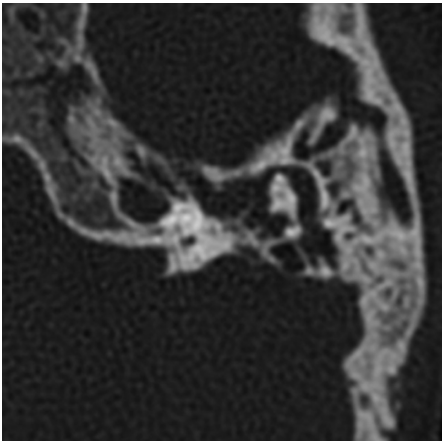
HRCT temporal bone, axial sections, bone window shows CLA with aplastic or hypoplastic petrous bone thereby no inner ear structures are visualized and dura is seen right next to the middle ear.
